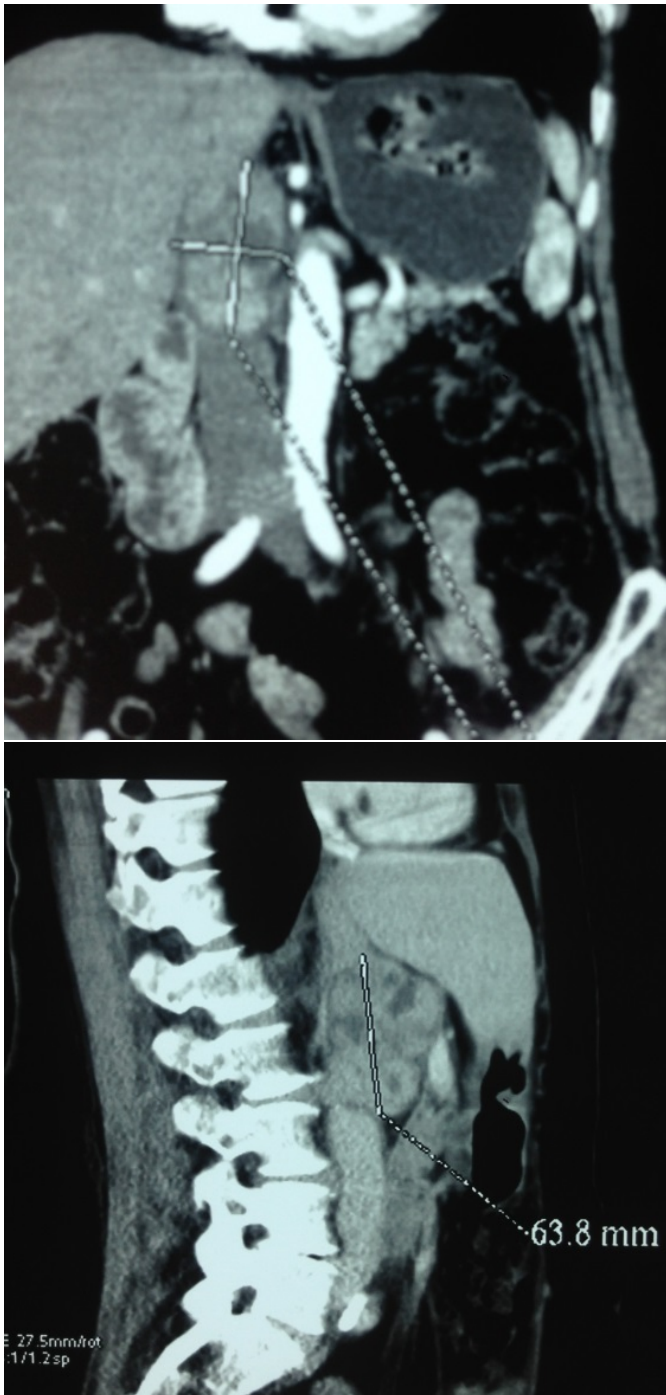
Contrast CT showing a mass originating from IVC.
